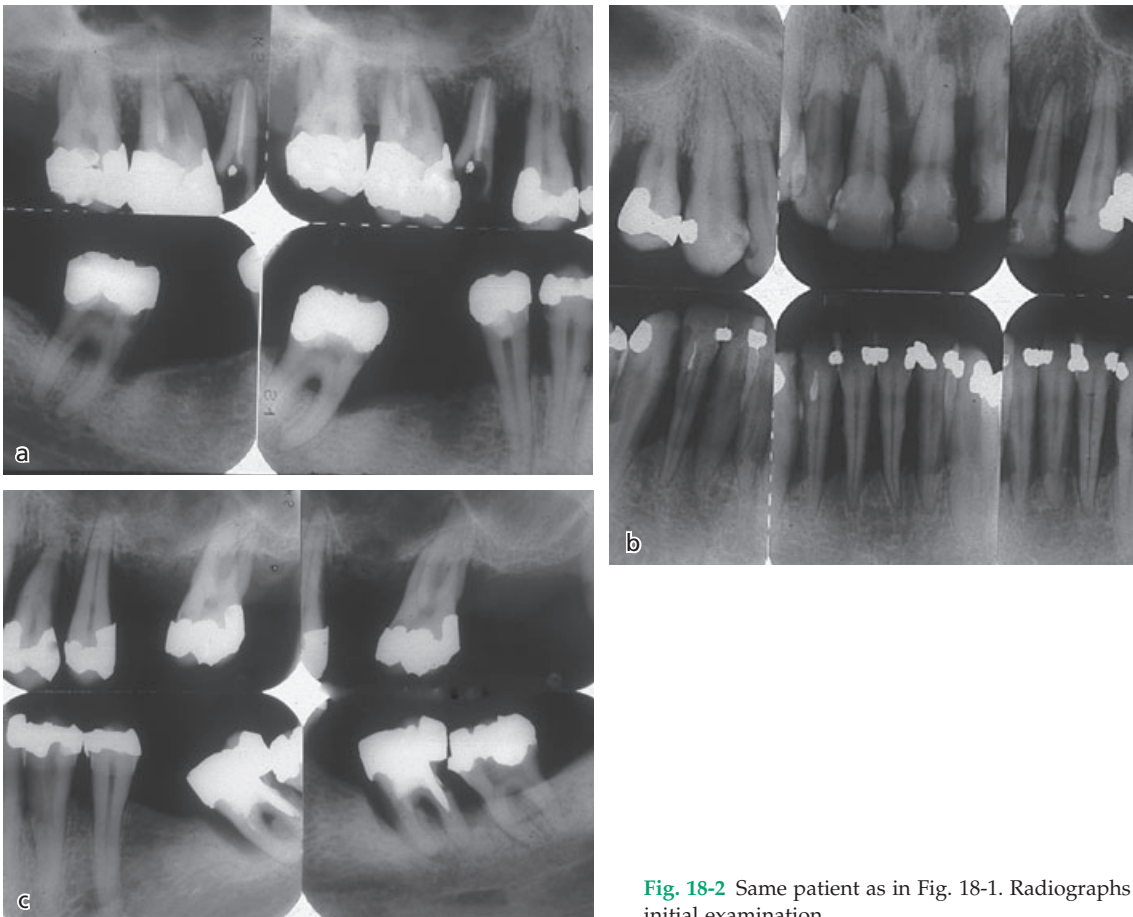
Same patient as in Fig. 18-1. Radiographs from the initial examination.
